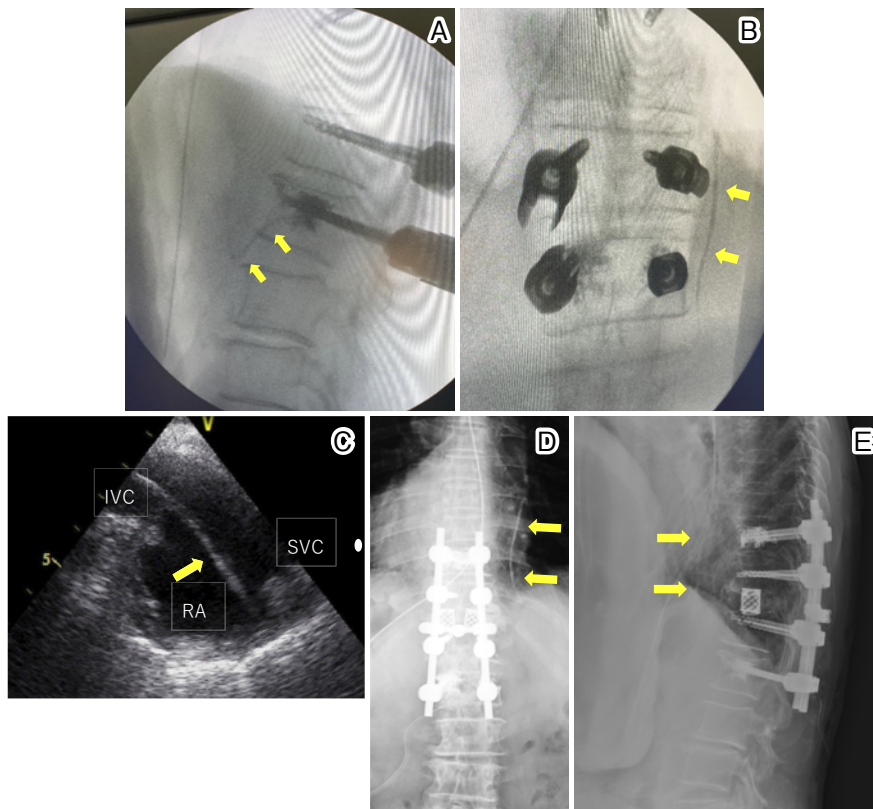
Bone cement leakage (yellow arrow) from the L2 pedicle was observed in the lateral view of fluoroscopy (A). Cement leakage (on the right side) into the inferior vena cava (B). Transesophageal echocardiography showed that the migrated cement reached into the right atrium and touched the interatrial septum (C). The post-VCR x-ray showed the migrated cement at heart level (D, E).
